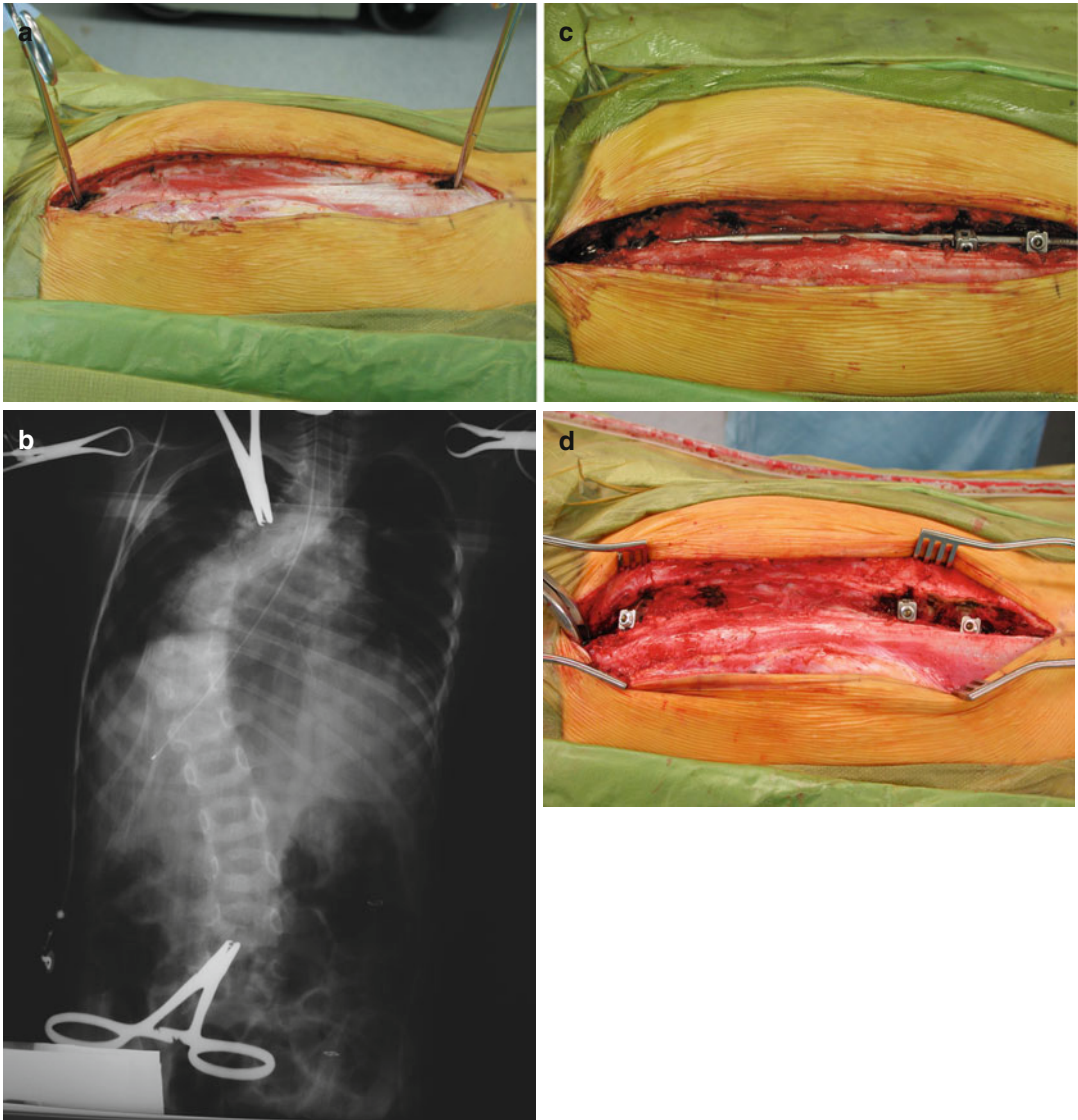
(a) Intraoperative photograph demonstrating the incision and the exposure for the upper and lower foundations. The spinous processes at the planned levels are identified and marked. A radiograph is obtained to confirm the preplanned levels. (b) Intraoperative anteroposterior (AP) radiograph demonstrating identification of the foundation sites. (c) Hooks are typically used for the upper foundation and hooks and/or screws for the lower foundation. Hooks spanning two vertebral segments for
